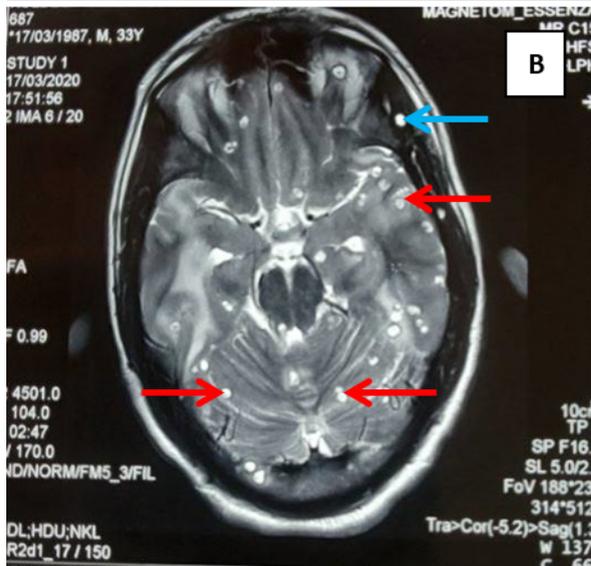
MRI Brain: T2W axial images (A&B) showing extensive involvement of entire brain parenchyma by multiple small cystic lesions with hypointense eccentric focus with surrounding perilesional edema; Frontal, occipital lobe (Red arrows-A) and scalp involvement (Blue arrow-A) & Temporal lobe and cerebellar involvement (Red arrows-B) & scalp (Blue arrow-B).
